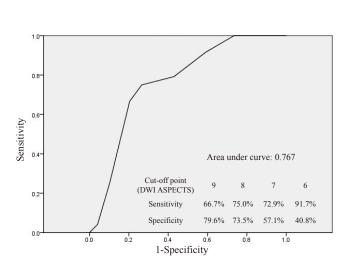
Receiver operating characteristic curves for the ability of the DWI ASPECTS to predict favorable outcome (mRS 0-2).
